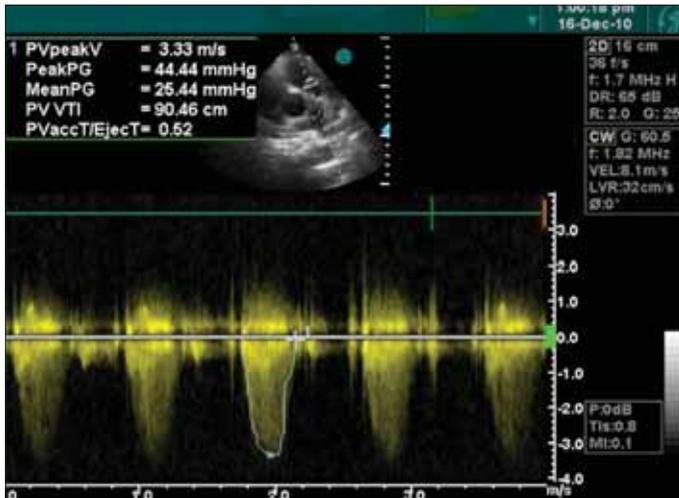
Continuous wave Doppler trace of the transpulmonary valvular mean gradient of 25 mmHg
